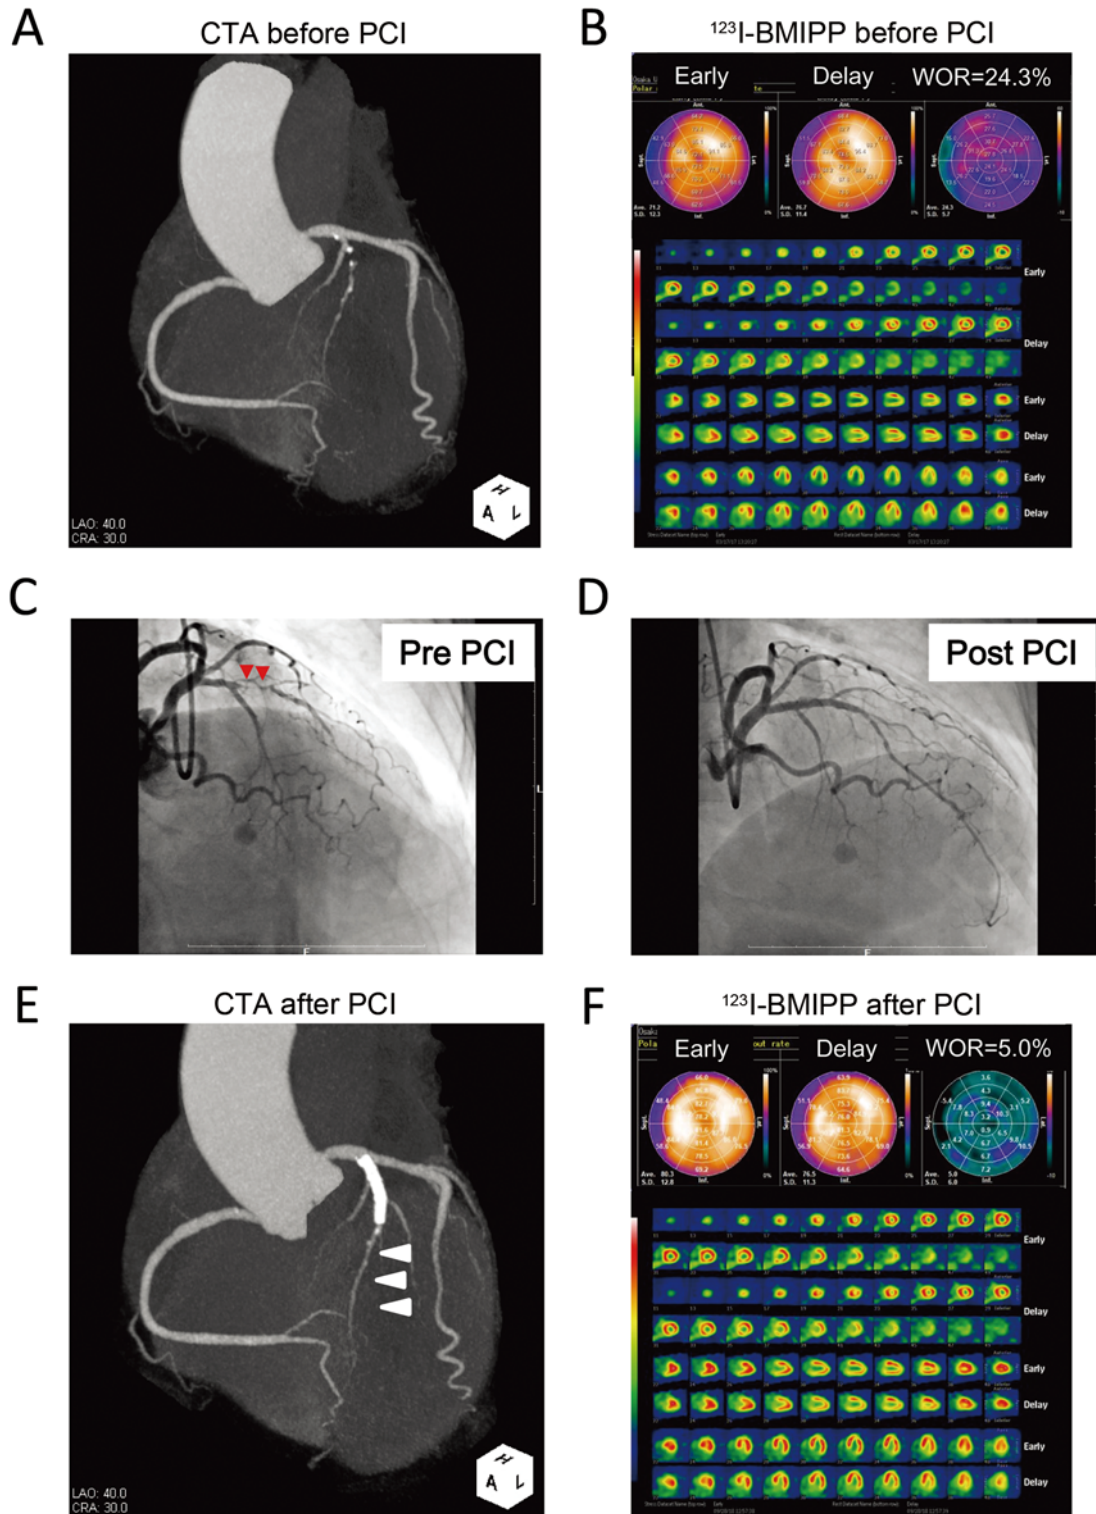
Computed tomographic (CT) angiograms, invasive coronary angiograms, and ¹²³I-BMIPP scintigraphy before and after percutaneous coronary intervention (PCI).
